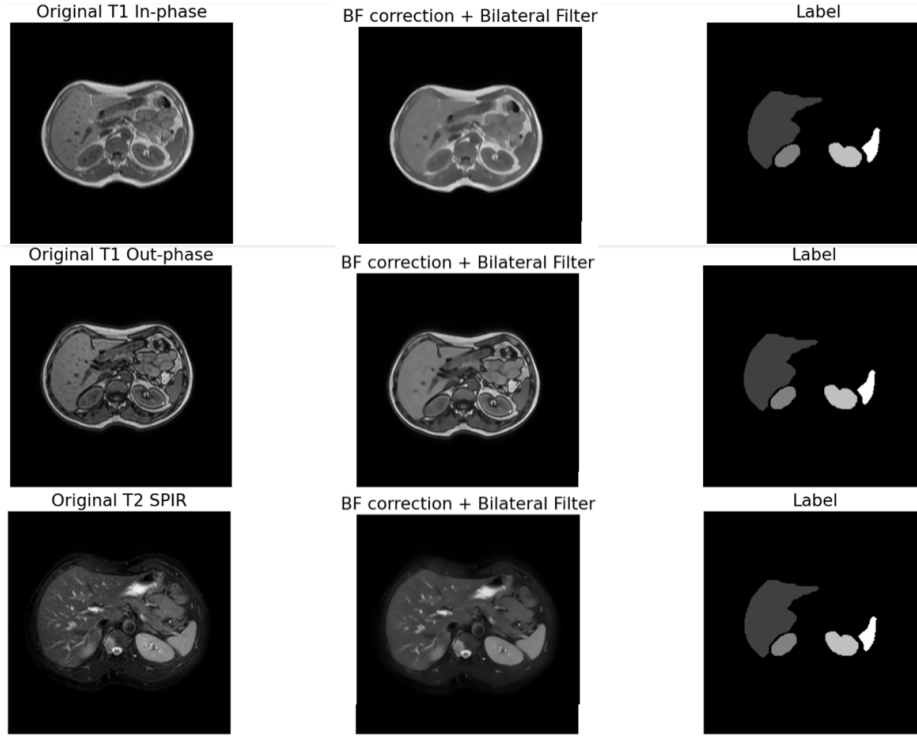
Pre-processing result of MR images.
